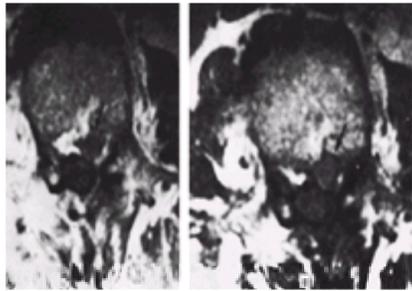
Free fragment disk L2-L3 rupture as seen on axial magnetic resonance imaging scan. Scar tissue from prior surgery enhances; disk fragment does not. A: Unenhanced scan. B: Gadolinium-enhanced scan. Arrow points to free fragment of disk. The patient had severe left L-2 radicular pain and paresthesia.
